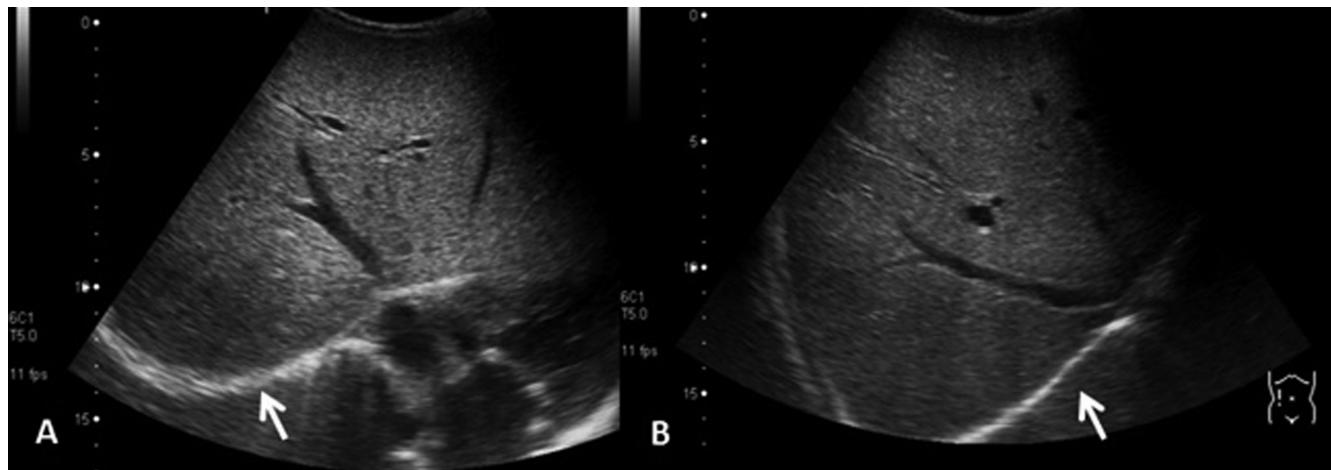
Ultrasound. Ultrasound examination the diaphragm appears as a thin hyperechoic line, viewable in a better way on the right, in opposition of the adjacent homogeneous hypoechoic liver parenchyma. The echographic technique enables the evaluation “real time” of the excursion of the hemi-diaphragms and any paradoxical movements.
